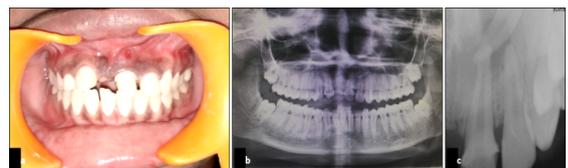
Preoperative clinical view, draining sinus tract wrt 21 (a), Preoperative radiograph Showing the periapical lesion and impacted supernumerary tooth in the periapical area of 21, 22 (b, c).
